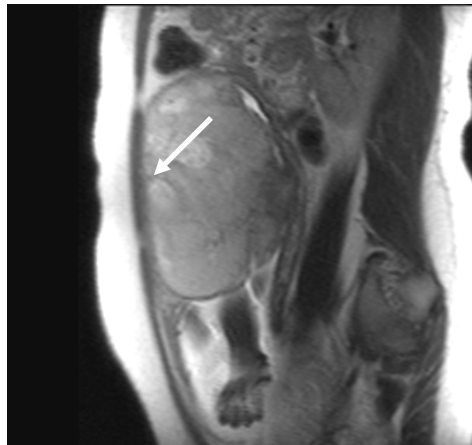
IUGR with morphologic signs and in diminished FVs a 23-year-old pregnant woman at 33 weeks gestation. T2-weighted RARE image shows the thick placenta and decreased size of flow voids between the uterus and the placenta (arrow)
